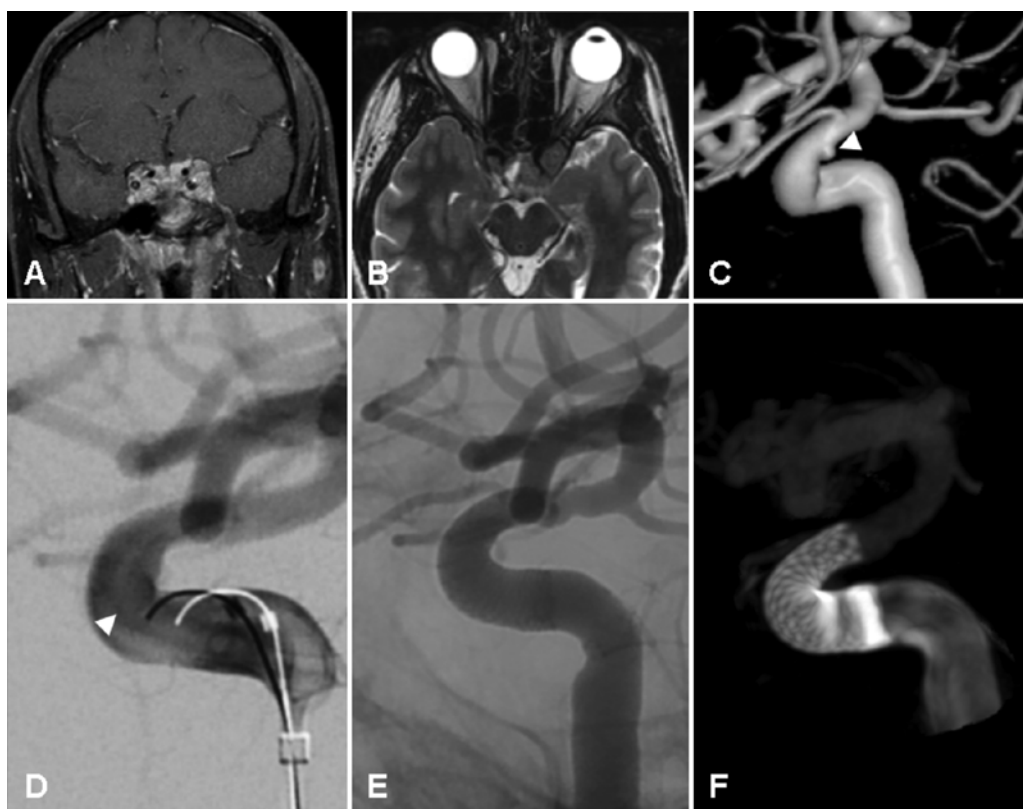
Case 5. A and B: Preoperative coronal T1-weighted gadolinium-enhanced (A) and axial T2-weighted (B) MR images showing distorted ICA anatomy following prior transsphenoidal surgery and recurrence of a large pituitary adenoma. C and D: 3D rotational reconstruction and arterial phase angiographic images obtained 5 days after surgery showing a 2-mm right ICA pseudoaneurysm proximal to the junction of the cavernous and clinoid segment of the ICA (white arrowheads). E and F: Arterial phase and dyna CT scan showing placement of a PED.
